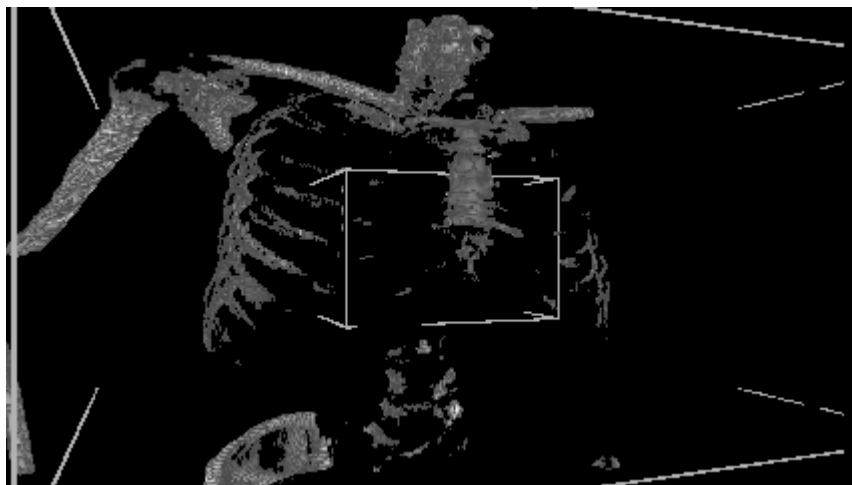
Negative parallax of left CT projection. Pixels need to switch to the right CT.
